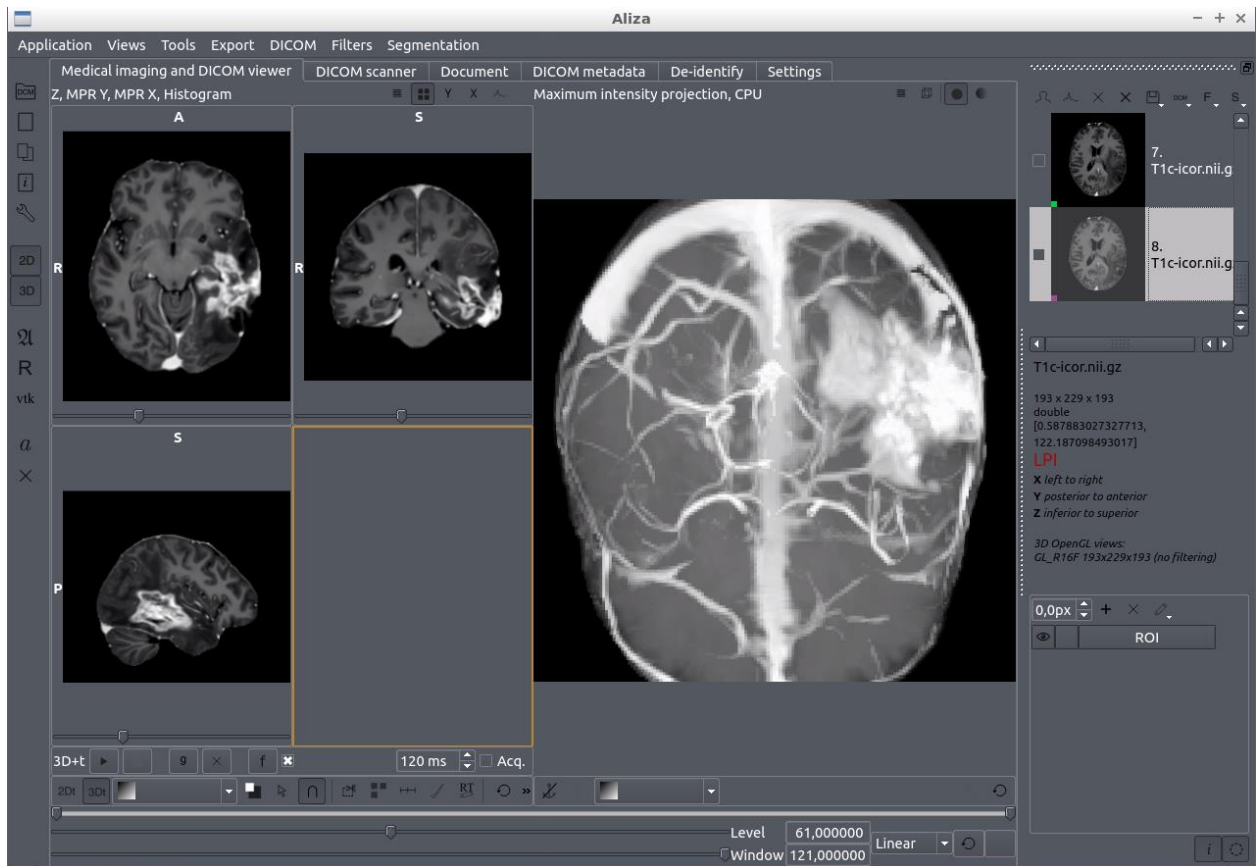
Scriptable visualization of preprocessed T1wc MRI in Aliza. This is subject nine from our second cohort.
